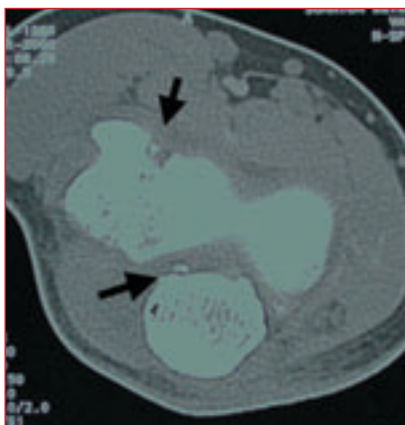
CT of the elbow showing loose bony fragments from osteochondritis dissecans of the humeral capitellum in the joint space.
